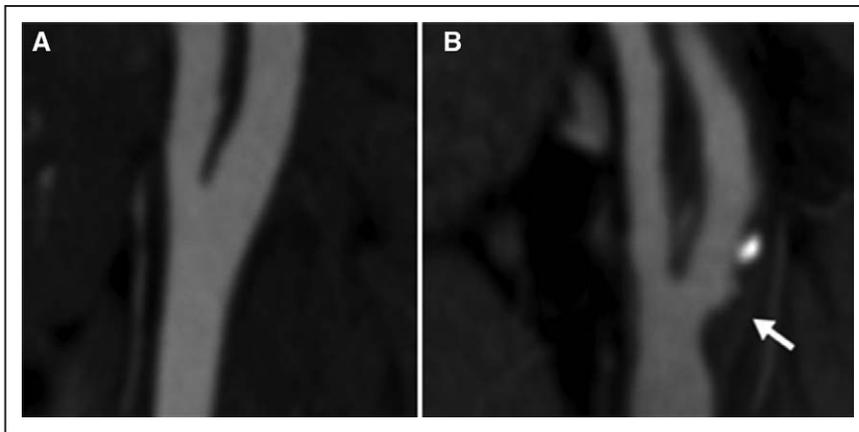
A computed tomography (CT) neck image of the right carotid artery in a uninfected individual free of carotid plaque (A) as compared with a neck CT image from a people living with HIV (PLWHIV) with carotid plaque with a non-calcified component (B, arrow).
